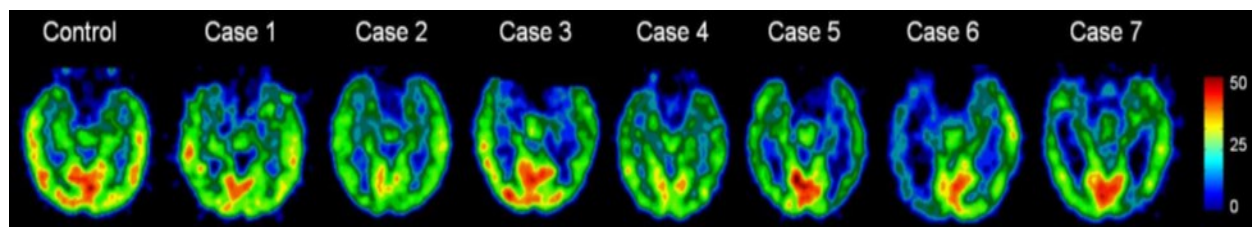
FDG-PET scans showing medial temporal lobe hypometabolism for each subject as compared to a healthy normal control. [Mosconi 2009] (Reproduced with permission).
